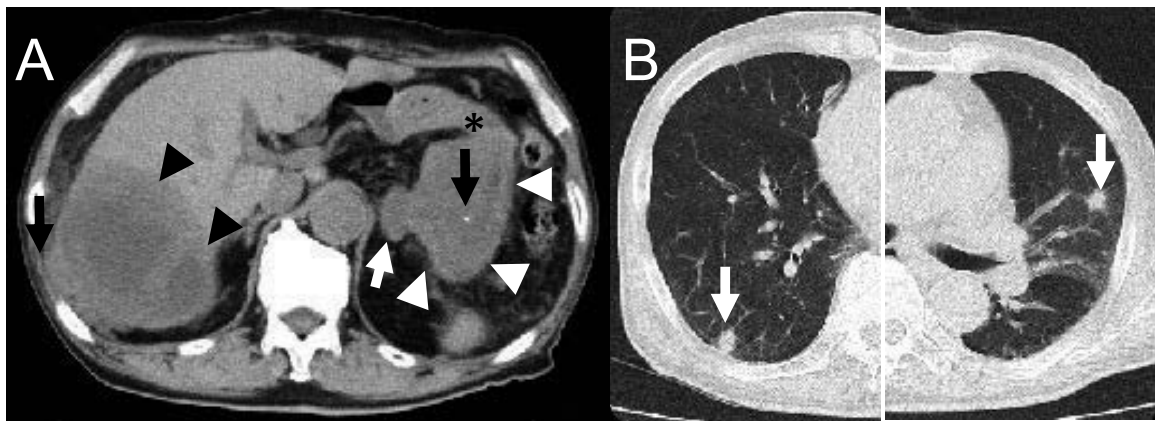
Abdominal computed tomography (CT) revealed a tumor (white arrowhead) of iso-density but heterogeneous internal structure, contiguous with the stomach (*) at the pancreatic tail, containing internal calcifications (black arrow). Additionally, it was associated with lymph node enlargement (white arrow), iso-density metastasis with low-density central area in the right lobe of the liver (black arrowhead), and an irregularly shaped mass within the abdominal cavity (black arrow) (A). Chest CT demonstrated high-density bilateral pulmonary metastases (white arrows) (B).
